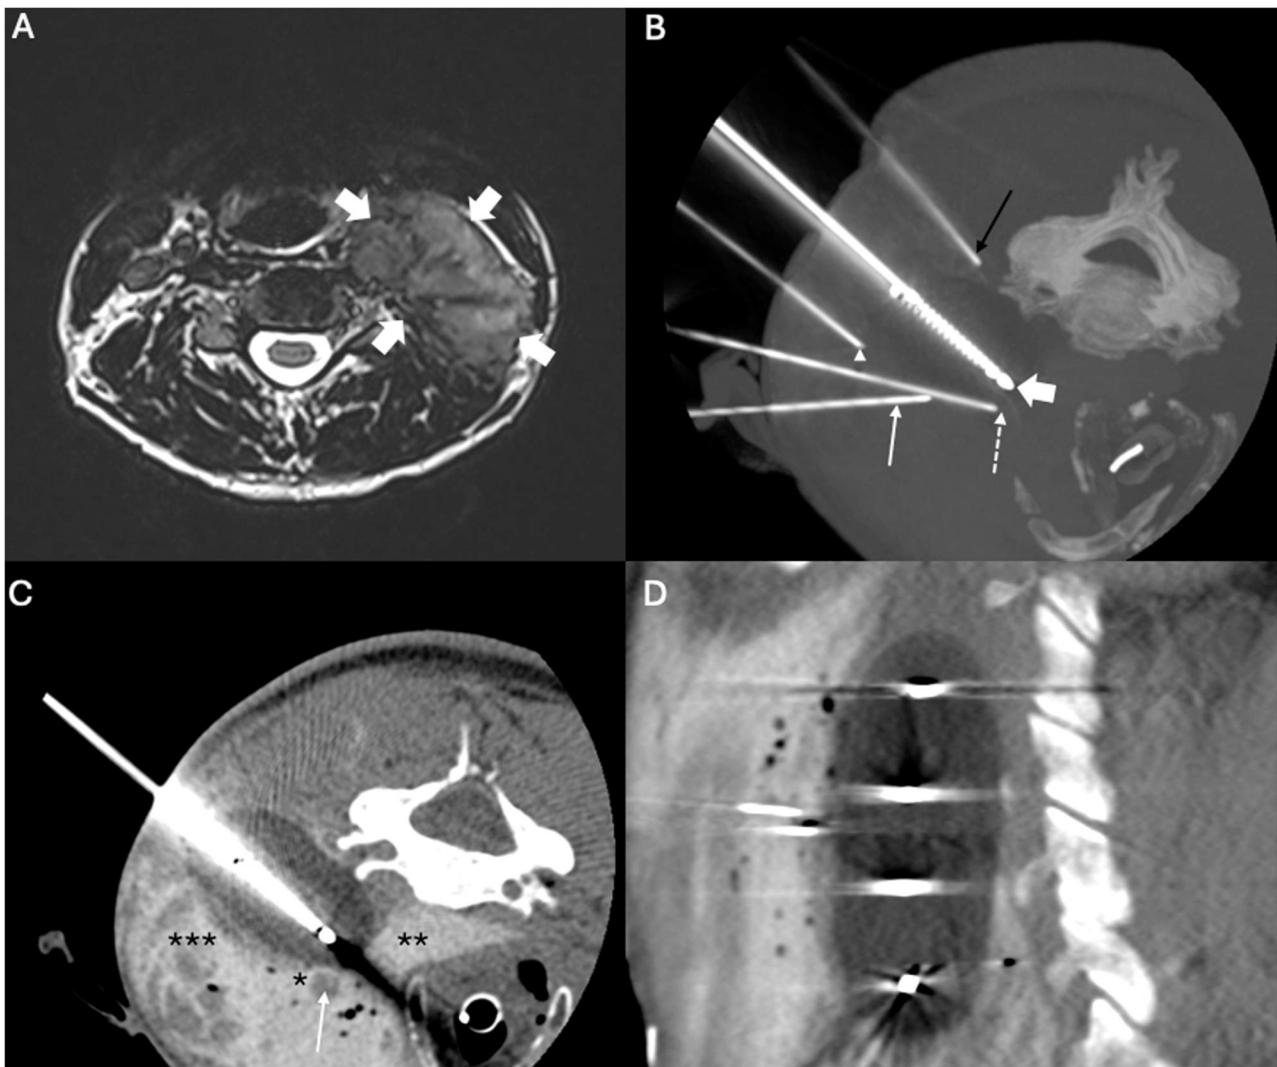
CA of a DF located in the neck. Axial T2 MRI (A) shows a DF located next to the pharyngeal space medially, the jugulocarotid space anteriorly and the cervical plexus posteriorly. Axial MIP CT scan (B) shows a cryoprobe (large arrow) in the tumour. Four 22G spinal needles are inserted around the DF to dissect the C5 nerve root (black arrow), the sternocleidomastoidien muscle (arrowhead), the jugulocarotid space (white arrow) and the pharynx (dotted white arrow). Axial (C) and oblique sagittal (D) CT scan visualizes the hypodense iceball. Note the hydrodissection of the parapharyngeal space (double asterisk), the muscle (triple asterisk) and the jugulocarotid space (single asterisk) with the carotid artery (arrow). Despite extensive hydrodissection and neurophysiological monitoring of the C4 and C5 nerve roots (not shown), the patient suffered from laryngeal nerve palsy (unintended freezing of the vagal nerve), Claude-Bernard-Horner syndrome and C5 palsy. Symptoms partially resolved at 1-year follow-up. Abbreviations: CA = cryoablation; DF = desmoid fibromatosis.
